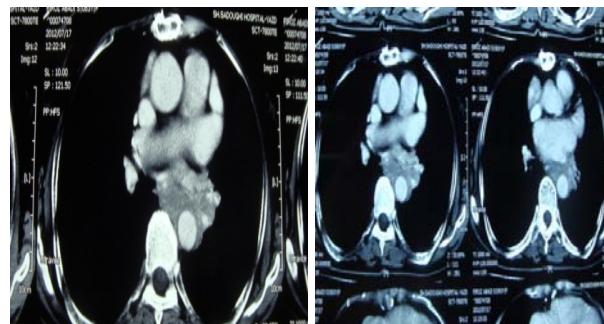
CT scan shows an abnormal soft tissue mass with irregular borders around the esophagus, aorta and left main bronchus.
